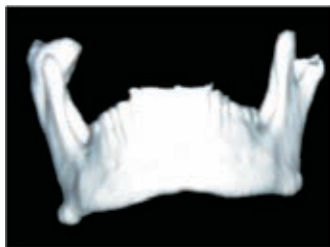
Medial extent in 3D CT
